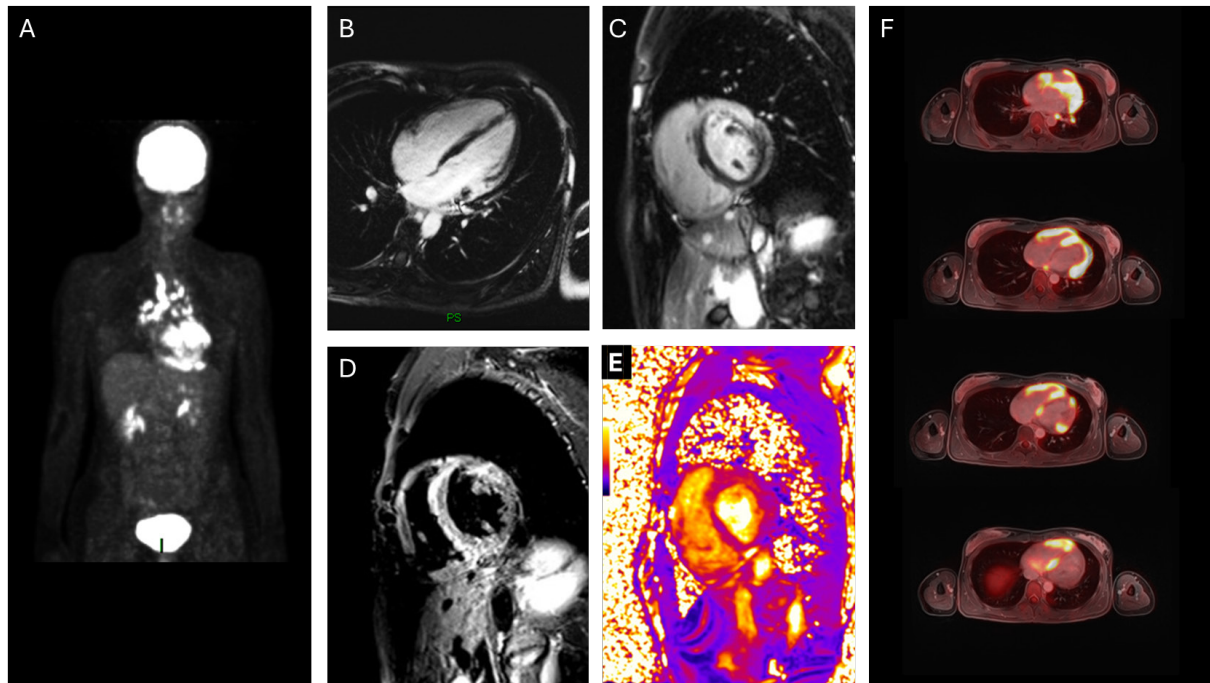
Hybrid ^{18}F -FDG PET-CMR (3 T system) prior to initiation of immunosuppressive therapy. (a) Whole-body maximum intensity projection image demonstrating heterogeneous myocardial FDG uptake, without significant extracardiac hypermetabolic foci apart from small mediastinal lymph nodes. (b) Four-chamber view cine CMR showing non-dilated left ventricle with preserved systolic function (LVEF 53%) and no regional wall motion abnormalities. (c) and (d) LGE imaging showing heterogeneous mid-wall and subepicardial enhancement involving the basal and mid-anterior and anterolateral segments, with additional involvement of the basal inferolateral wall and focal enhancement of the right ventricular free wall. (e) Parametric mapping demonstrating increased T2 values ($52\text{--}53\text{ ms}$) in the basal inferolateral and anterior segments, consistent with active myocardial inflammation. (f) Fused axial FDG PET-CMR images demonstrating intense, heterogeneous FDG uptake in the inferolateral and anterior walls, basal interventricular septum and right ventricular free wall, co-localising with regions of LGE, confirming active inflammatory cardiomyopathy. ^{18}F -FDG, ^{18}F -fluorodeoxyglucose; LGE: Late gadolinium enhancement; PET-CMR: Positron emission tomography-cardiac magnetic resonance.
